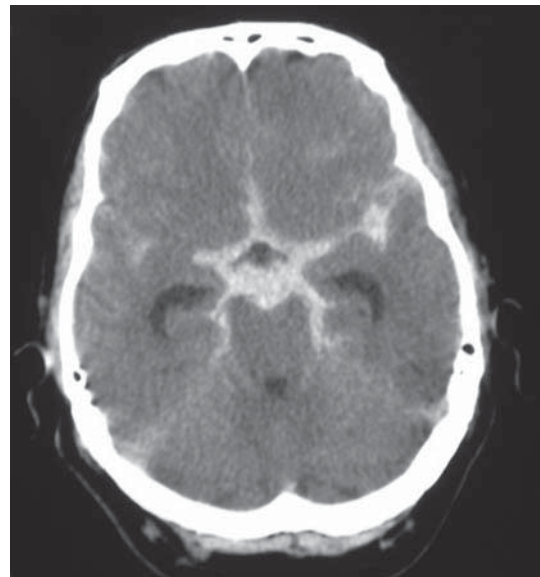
Initial CT scan showing a Fisher grade 3 subarachnoid haemorrhage.
